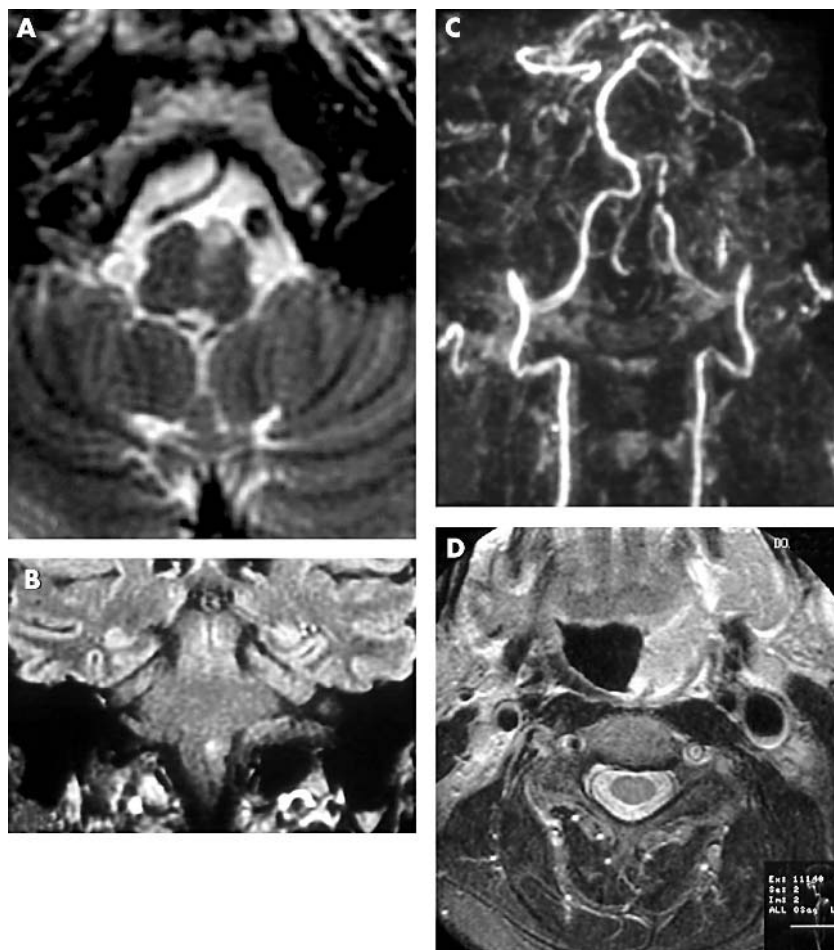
Axial T2 weighted (A) and coronal FLAIR (B) sequences showing signal abnormality involving the left pyramid, anteromedial olive, and lemniscal region of the medulla. There was corresponding signal change suggesting restricted diffusion, consistent with acute infarction, on diffusion weighted imaging (not shown). Contrast enhanced magnetic resonance angiography (C) showed irregularity of calibre of the left vertebral artery. It was confirmed that this represented dissection on axial images of all pulse sequences, including fat suppression images (not shown), and T2 weighted image (D), which in addition shows the crescent sign of dissection.
